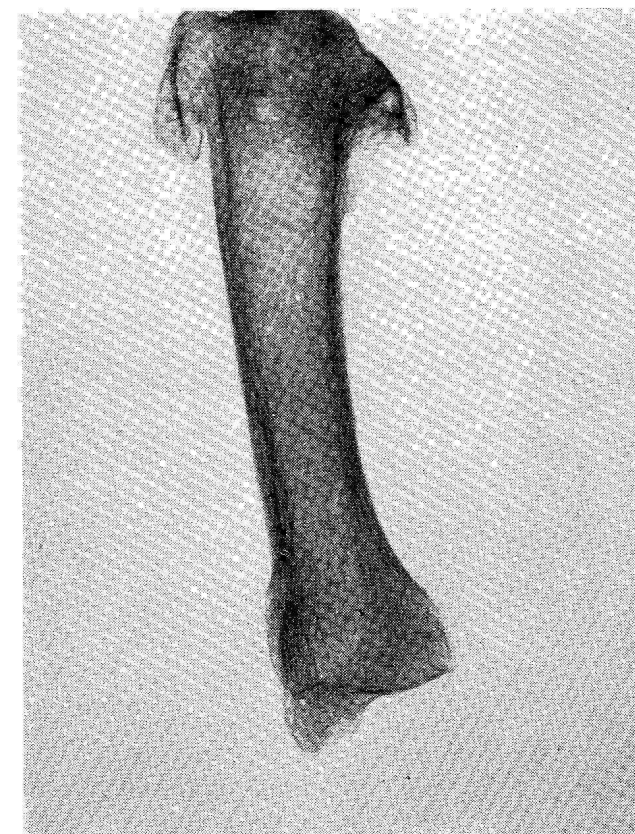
Roentgenogram. Deforming arthrosis of hand bone head (Arthrosis deformans capitis ossis metacarpalis). Burial No. 230.
